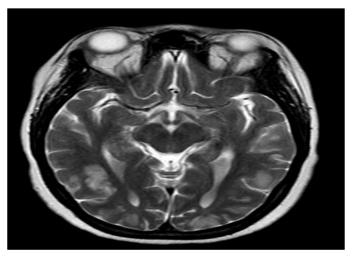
MRI Image - PRES (Parieto Occipital Region)
